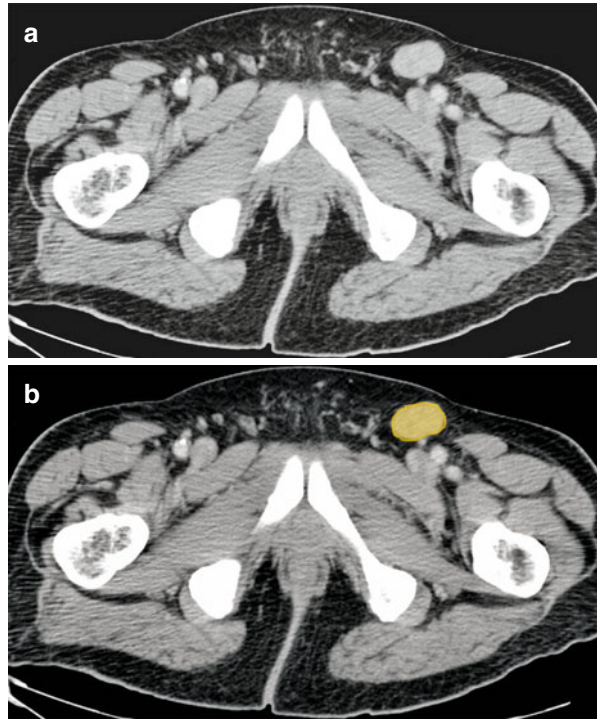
Axial CT image shows the locations of the superficial inguinal nodes (*orange*)
